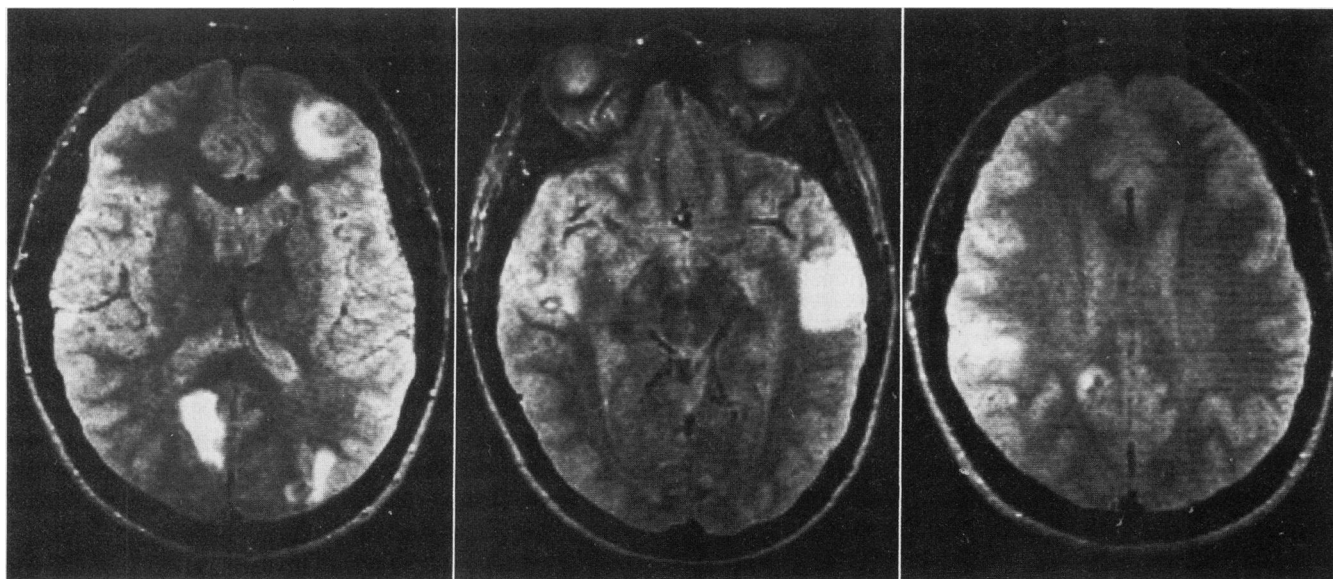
Patient 1. Spin-echo magnetic resonance images (repetition time 2,000 ms, echo-delay time 80 ms) showing areas of increased intensity in the left frontal lobe (left) and bilaterally in the temporal (middle) and occipital lobes (right). Many more lesions are shown than with computed tomography (compare with Figure 1). Also, the borders of these high-intensity lesions conform to the shape of the surrounding sulci (see text).
